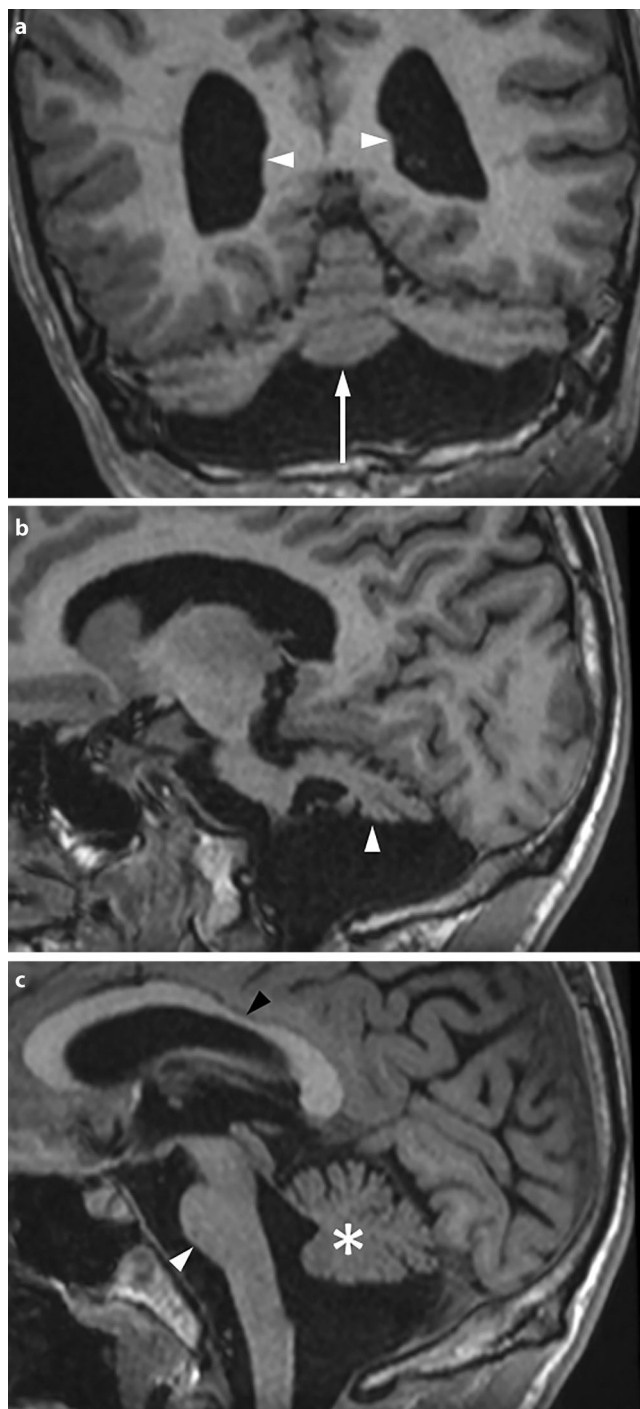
a–c T1-weighted gradient echo sequence images in a 17-year-old patient with a history of cerebellar disruption following extreme prematurity. Emergency cesarean section was performed at 27 weeks gestational age. a The coronal image shows cerebellar hypoplasia with the vermis (*arrow*) being less affected, therefore leading to a “dragonfly pattern”. Mild colpocephaly (*arrowheads*) is the result of periventricular leukomalacia. b A sagittal slice through the superior cerebellar peduncle depicts marked hypoplasia of the cerebellar hemisphere (*arrowhead*). c The mid-sagittal image shows the vermis (*asterisk*) to be relatively preserved. The pontine protuberance (*white arrowhead*) appears reduced and an exceptionally pronounced callosal isthmus (*black arrowhead*) reflects some white matter loss
